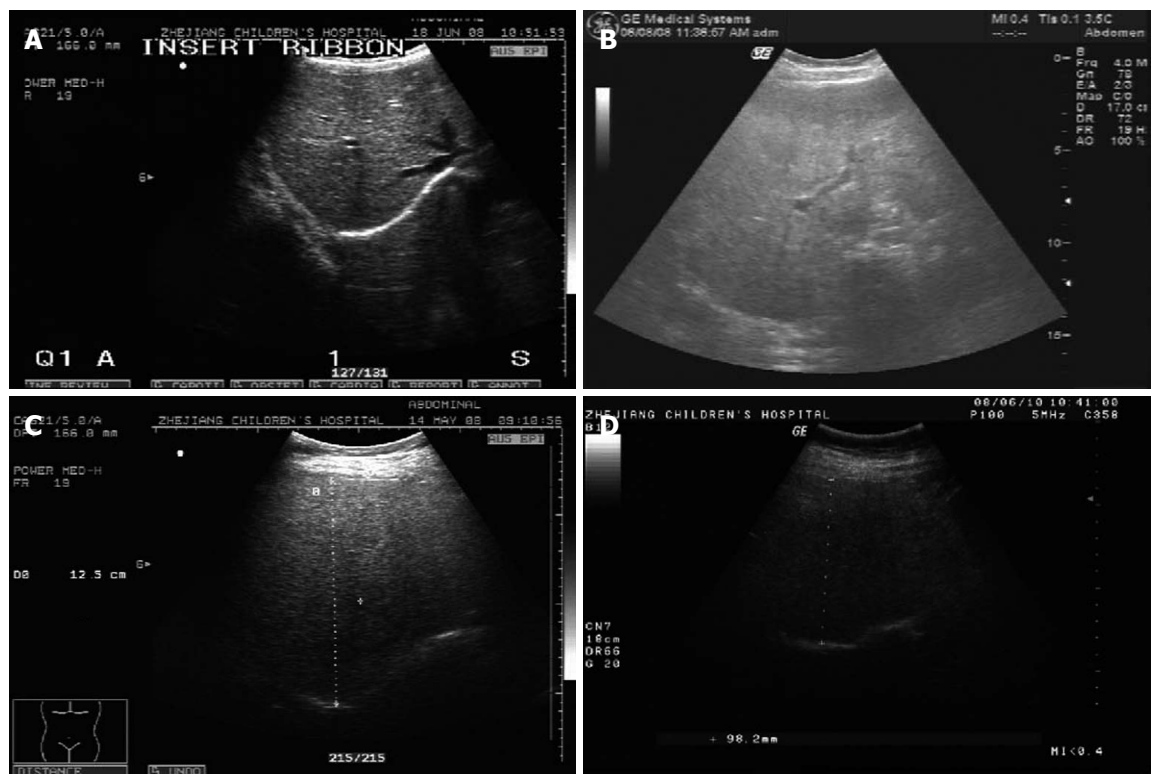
Liver B-ultrasound scans show the panel of four different classes of liver steatosis. A: Class 0: not observed; B: Class 1: mild, liver-kidney contrast without vascular blurring and deep attenuation; C: Class 2: moderate, liver-kidney contrast with vascular blurring, but no deep attenuation; D: Class 3: severe, combination of liver-kidney contrast with vascular blurring and deep attenuation.
